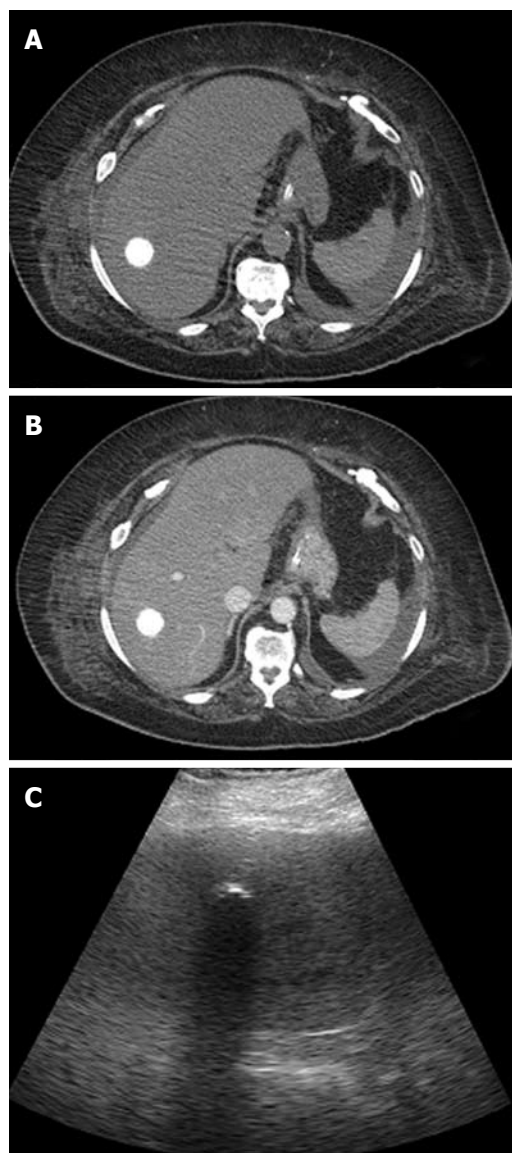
Seventy-three year-old-woman with a dead hydatid cyst. Computed tomography scan basal and enhanced images (A, B) show a totally calcified cyst (type III). At ultrasonography (C) calcified cyst shows strong posterior shadowing.
